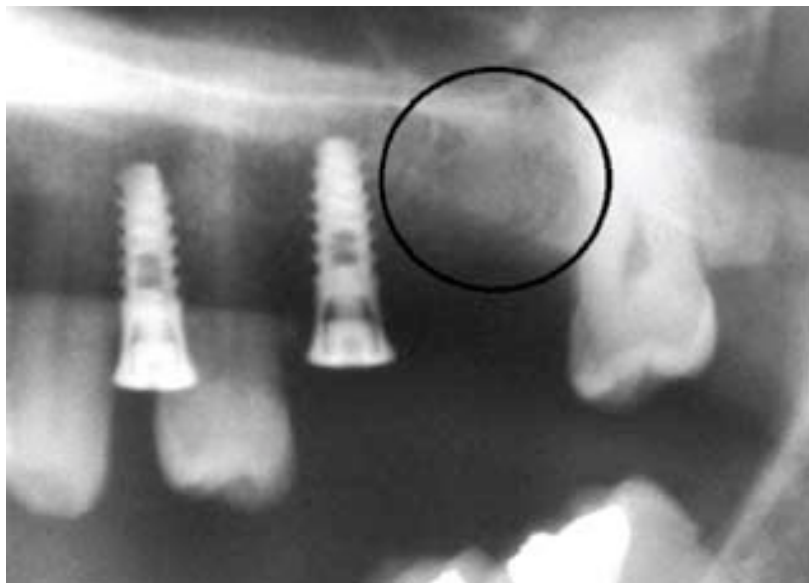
Radiograph indicating increased opacity at the failed implant site 3 months after the implant removal and placement of L-PRF clot in the area.
